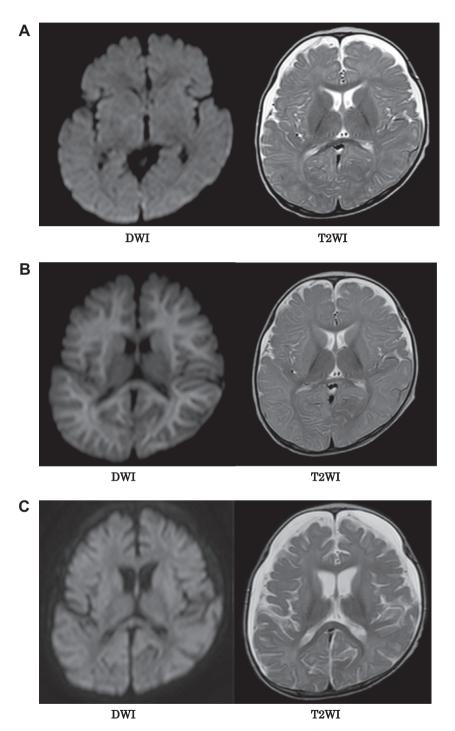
(A) Brain magnetic resonance imaging (MRI) performed on admission failed to identify parenchyma injury. DWI, diffusion-weighted image; T2WI, T2 weighted image. (B) MRI performed on day 5. Note the hyperintensity in the deep subcortical white matter. (C) MRI performed on day 19. The hyperintensity on DWI resolved, but diffuse cerebral atrophy was observed.
